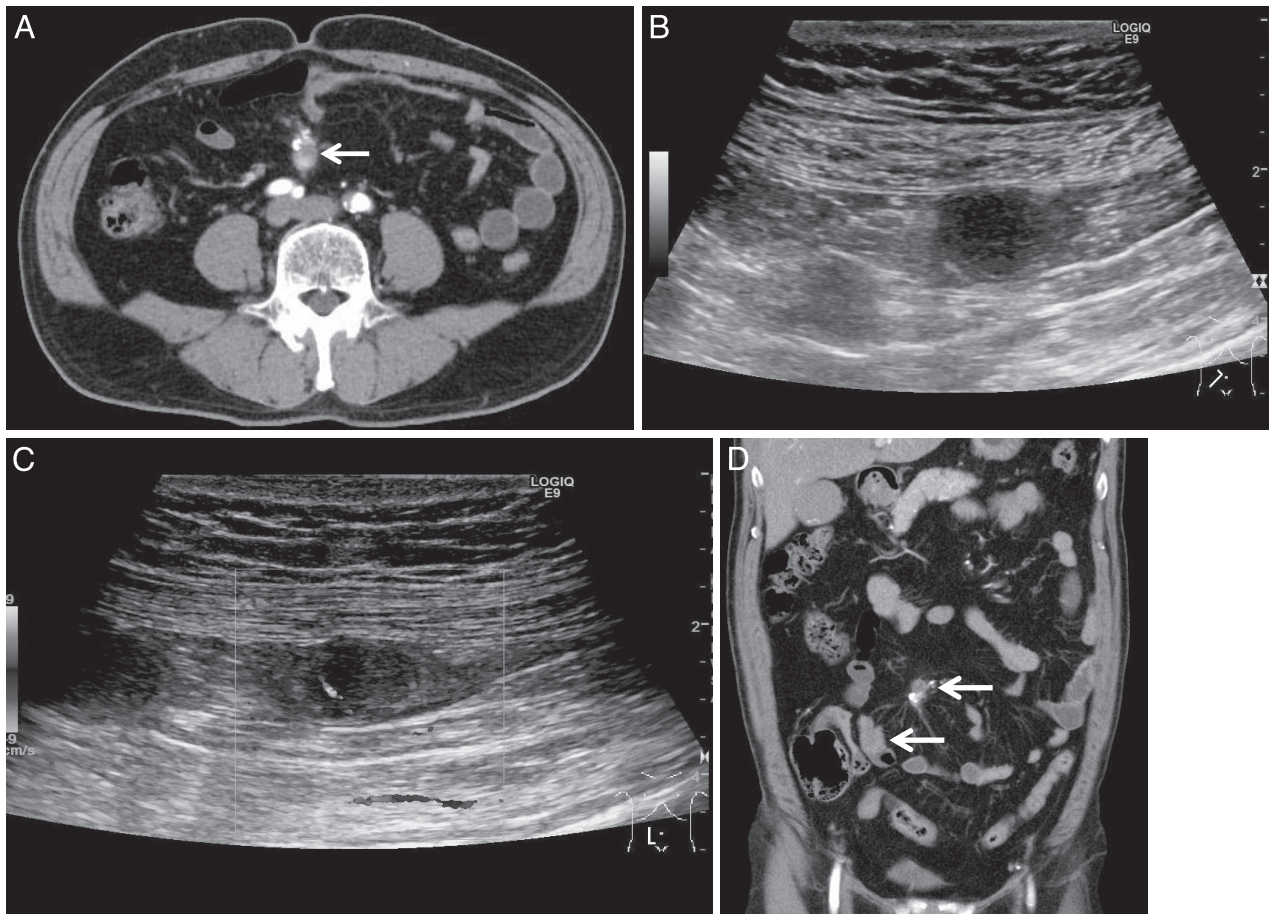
(A) A contrast-enhanced CT image shows a tumor lesion (arrow) with partial contrast enhancement and calcification of the lesion edge in the mesentery. The size of the tumor lesion is 15 mm. (B) An US image shows a well-defined hypoechoic, homogeneous tumor lesion in the small intestine near the tumor mass in the mesentery. The size of the tumor lesion is 15 × 9 mm. (C) A color Doppler image shows hypervascularity within the tumor. (D) A CT image shows a tumor lesion with weak contrast enhancement in the small intestine near the tumor lesion in the mesentery (arrows).
